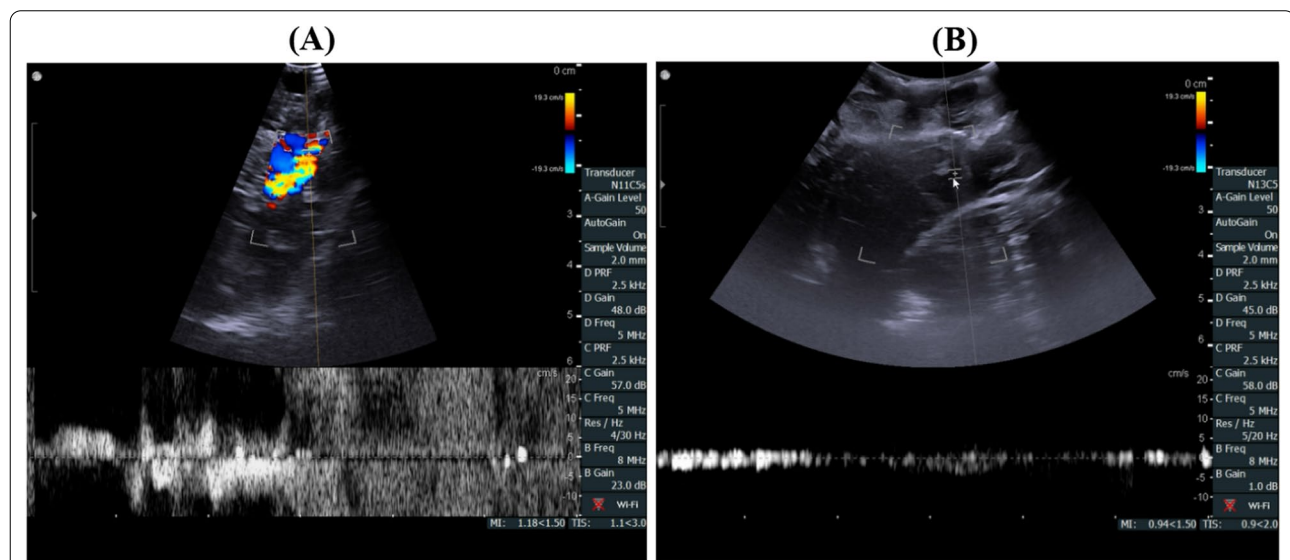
Use of ultrasound probe after dural incision
